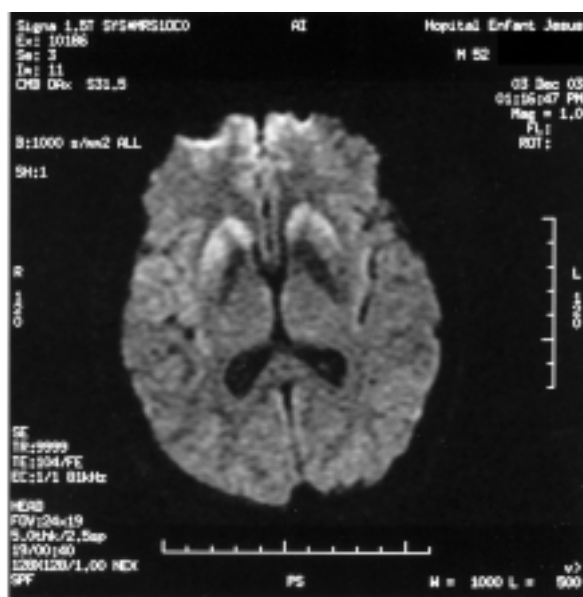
Diffusion-weighted MRI. Hyperintensities in the caudate and putamen nuclei are present bilaterally.
